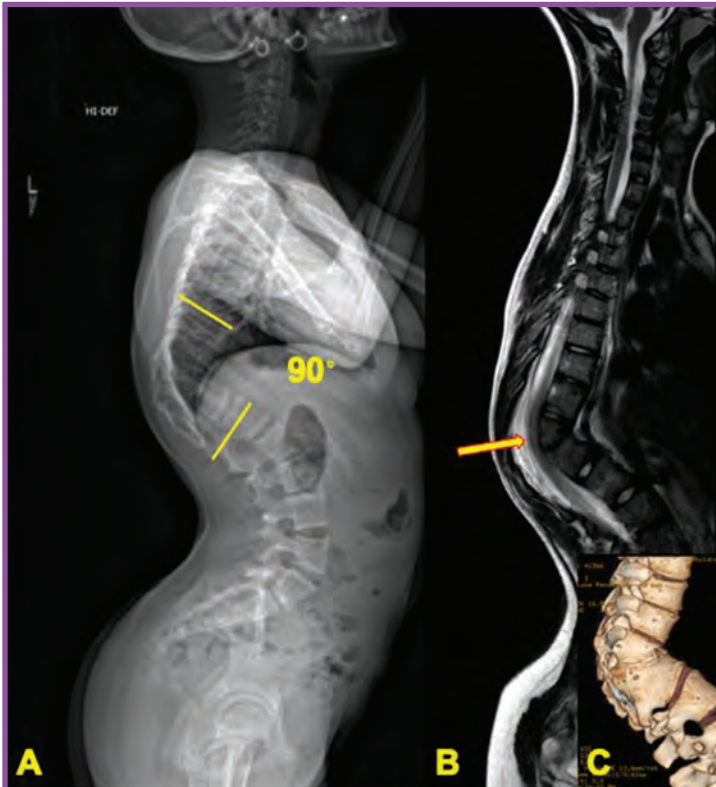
Lateral radiograph of the spine from a patient with severe thoracolumbar congenital kyphosis; straight lines indicate the kyphosis measured region (A). Sagittal T2-weighted magnetic resonance image demonstrates spinal cord compression over the apex of the deformity (arrow) (B). Three-dimensional computed tomography reconstruction shows congenital fusion at the thoracolumbar junction resulting in the severe congenital kyphosis (C).
